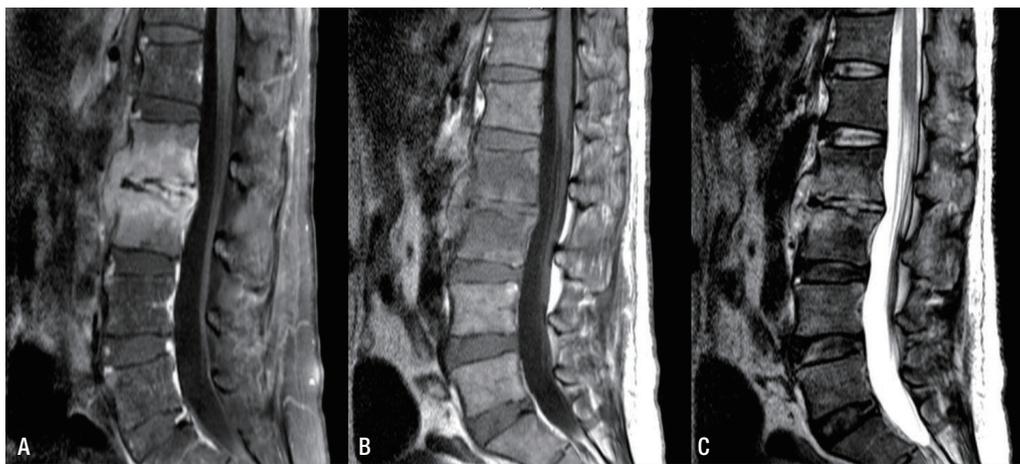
Spondylitis of the L2, L3 bodies with a prevertebral abscess is shown as low signal intensity on a T1-weighted image, high signal intensity on a T2-weighted image, and enhancement on a contrast media-enhanced T1-weighted image. (A) T1-weighted image, (B) T2-weighted image, (C) contrast media-enhanced T1-weighted image).
